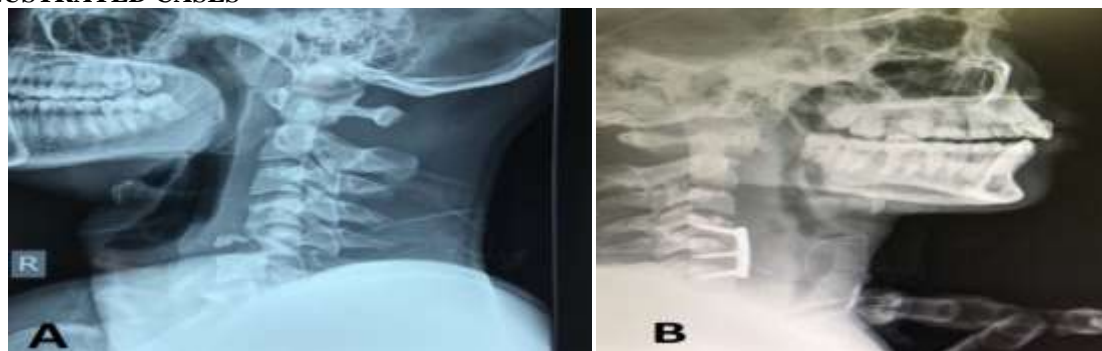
Pre-operative (A) and Post-operative (B) radiograph comparison of a 50 years old patient with cervical myelopathy who underwent C5-corpectomy with iliac crest autograft. Post-operative radiograph shows complete fusion.
